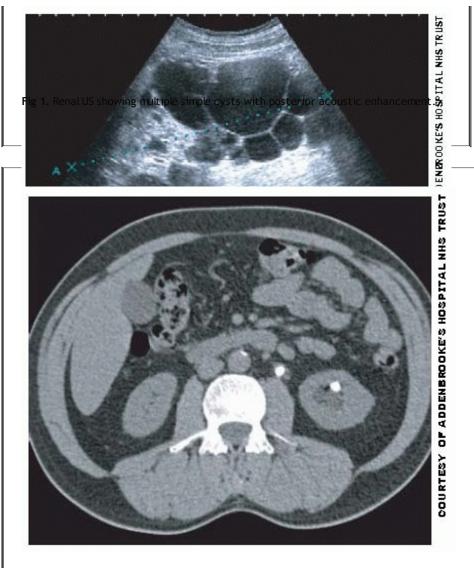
Axial unenhanced CT of the abdomen. There is a left proximal ureteric calculus (anterior to the left psoas) and a left calyceal calculus. The left ureteric calculus is causing mild obstruction of the left kidney. A bone window algorithm may help highlight calcium dense objects within the abdomen. If <7mm diameter, a calculus is likely to pass spontaneously.
